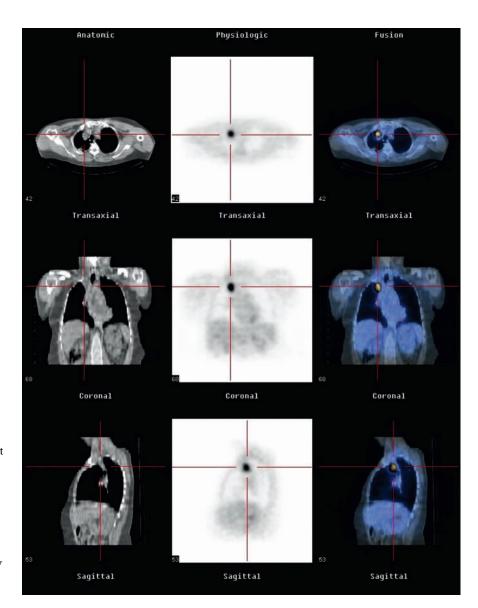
Images of a patient with small cell lung carcinoma imaged using combined CT and FDG PET.
